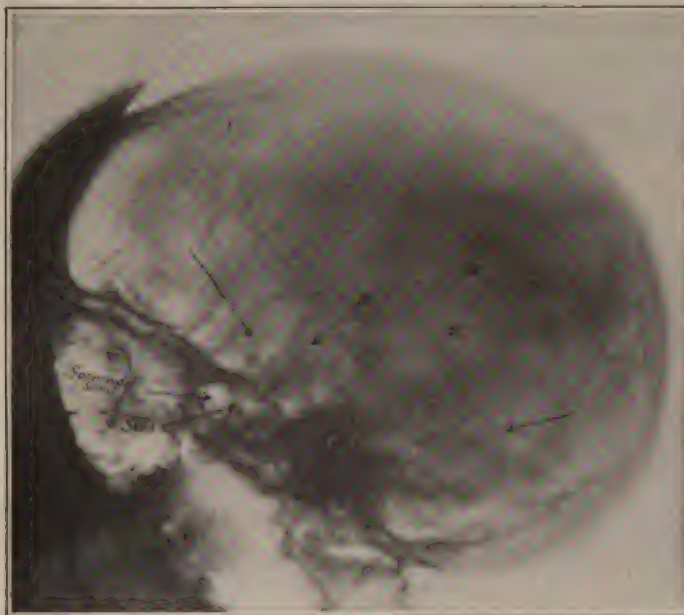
Teratoma of the Hypophysis cerebri. Note also the Dilated Lateral Sinus, and the Open Sutures. The +s Mark Internal Hydrocephalus. (X-ray Dept., J. H. H.)
